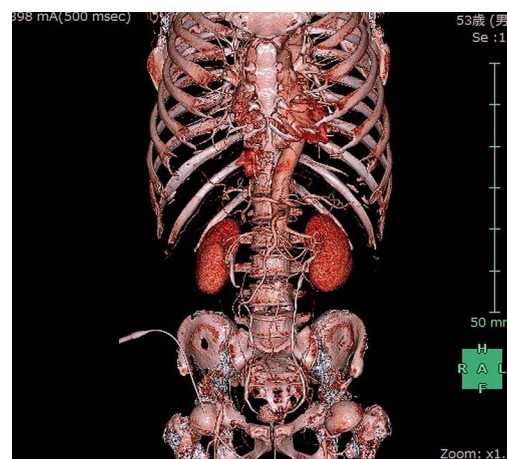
Three-dimensional CT reconstruction image.
